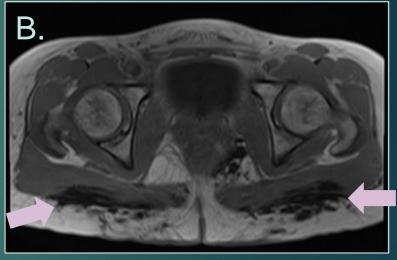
CT image demonstrates patchy soft tissue change in the deep subcutaneous tissues overlying the gluteus maximus muscle who had recent liposuction procedure. Figure B: T1W MR image demonstrates dark heterogeneous changes in the buttock muscles and in the overlying subcutaneous tissues in keeping with hemosiderin deposits from post-traumatic liposuction. No organized hematoma was seen.
